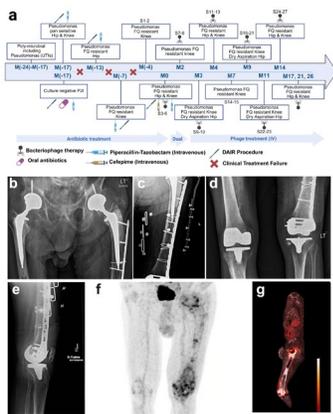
Clinical Timeline and Imaging. a. Clinical timeline of PJI course by months, b-e. Radiographs demonstrate complexity of implants and hardware, f-g. PET imaging of the pelvis and upper leg.
